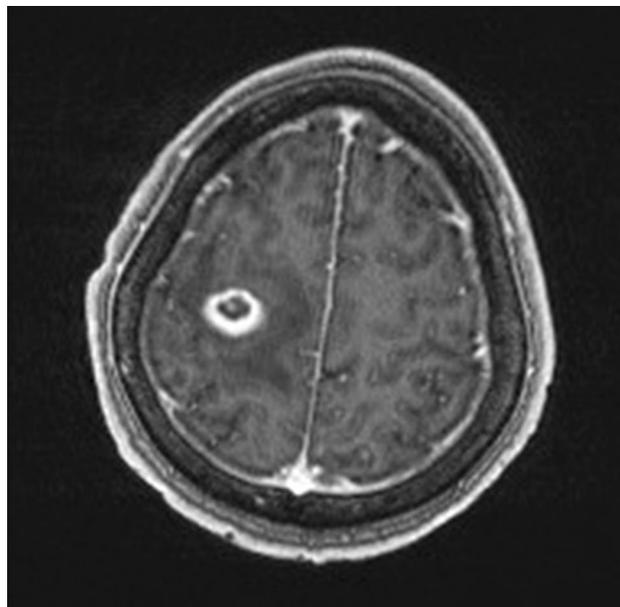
Cerebral magnetic resonance imaging, T1 MPR with contrast medium, axial ring enhancement with central necrosis and perifocal edema
